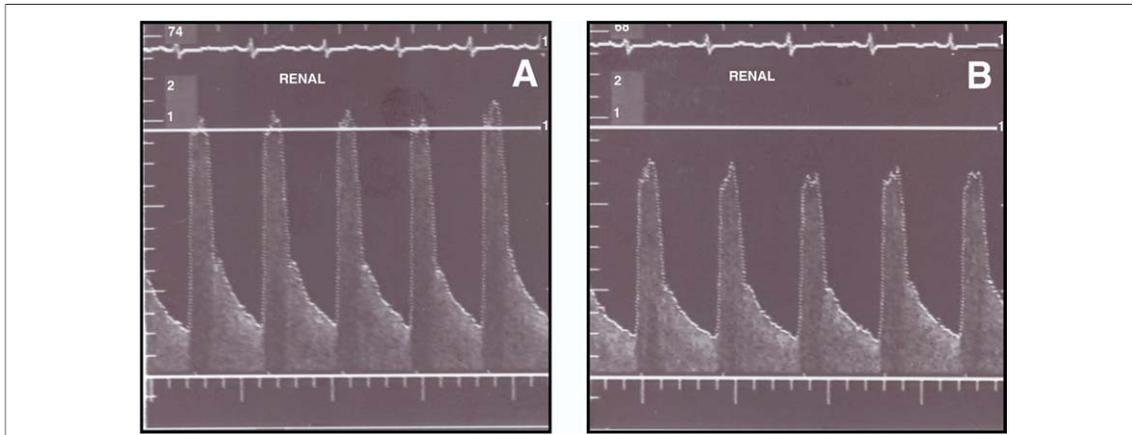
Example of Renal Artery Blood Flow Velocity Measured by Intravascular Doppler Technique
